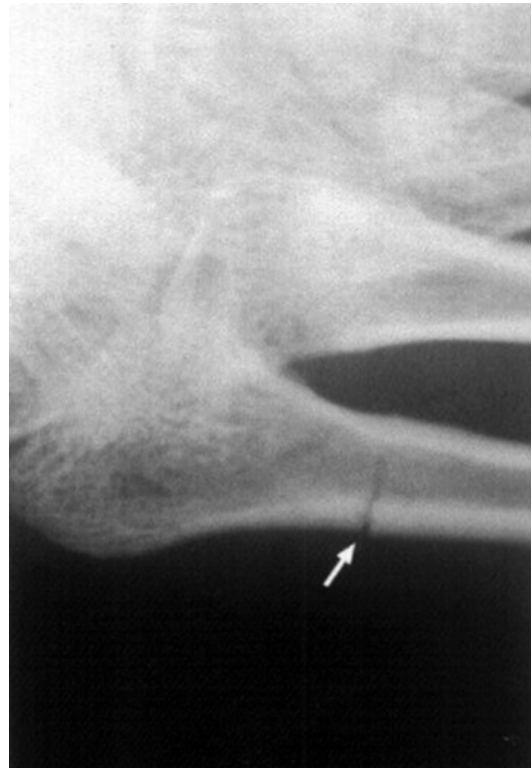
Stress fracture at the diaphysis-metaphysis junction in the fifth metatarsal bone, as seen on common radiography (X-RAY). This is an acute or Torg I fracture
